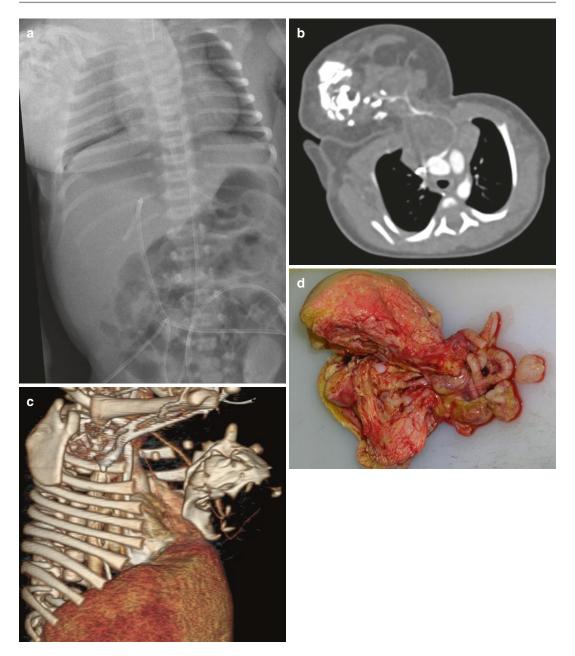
Teratoma of the chest wall. Plain film (a) demonstrates a large heterogenous chest wall mass containing some areas of calcific density. Axial contrast enhanced CT (b) and volume rendered 3D reformat (c) confirms the anterior chest wall mass containing calcific
